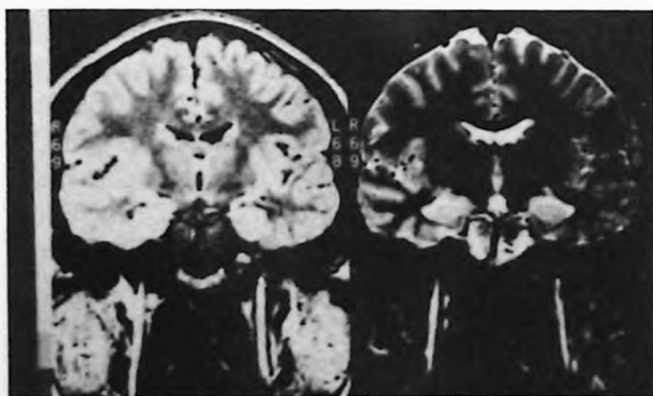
Ten-month follow-up MRI demonstrated marked improvement with no obvious signal range of the hippocampus.
